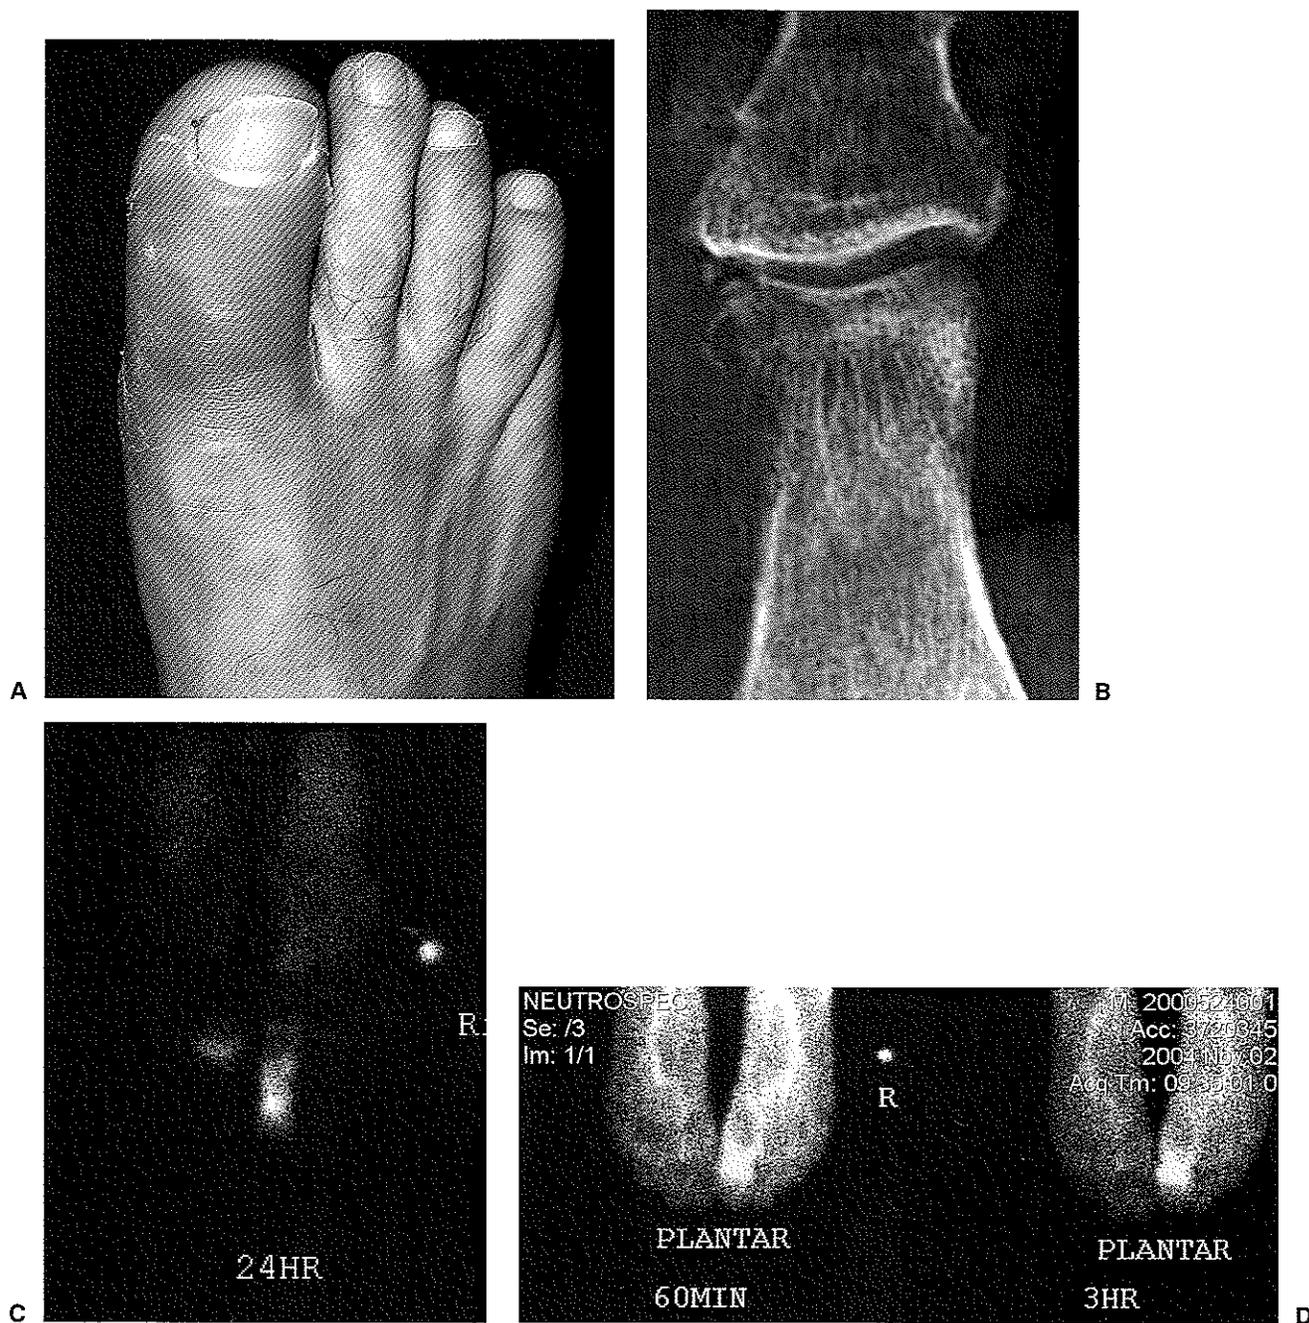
This series documents a diabetic patient who sustained a spider bite that was treated with many weeks of oral antibiotic therapy. Because of continued erythema, swelling, and pain infection imaging was pursued. A. Clinical evaluation reveals a tender, warm, swollen, and erythematous great toe. B. X-ray dorsal-plantar hallux reveals a fracture of the distal aspect of the proximal phalanx of the great toe. Arthritic changes in these regions can confound plain film interpretation and these subtle findings were overlooked upon initial presentation in the emergency room. C. ^{99m}Tc -MDP third phase suggests hyperemia within the hallux extending into the first metatarsal head. D. ^{99m}Tc -monoclonal antibody imaging performed at 60 minutes and 3 hours reveals the cubic morphology of the proximal phalanx consistent with osteomyelitis. Notice that the region of intensity found in this image set is more localized than that seen in the ^{99m}Tc -MDP scan. Partial débridement of the hallux proved curative, and indium leukocyte imaging confirmed absence of infection at long-term follow-up.
